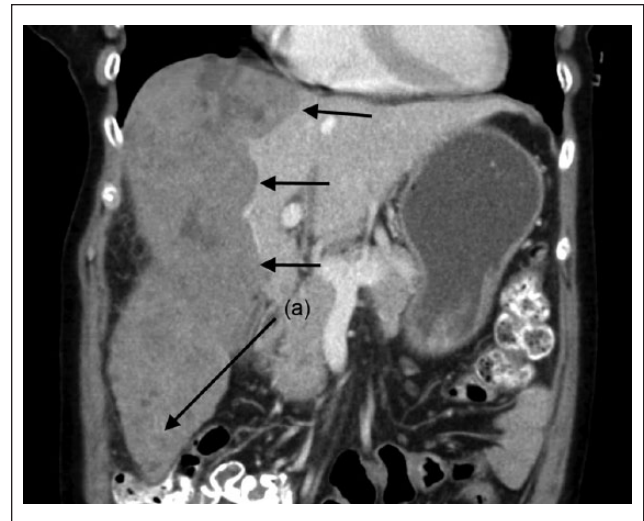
Computed tomography scan of September 22, 2014: Marked hepatomegaly and malignancy; liver extension into pelvic cavity (a).
